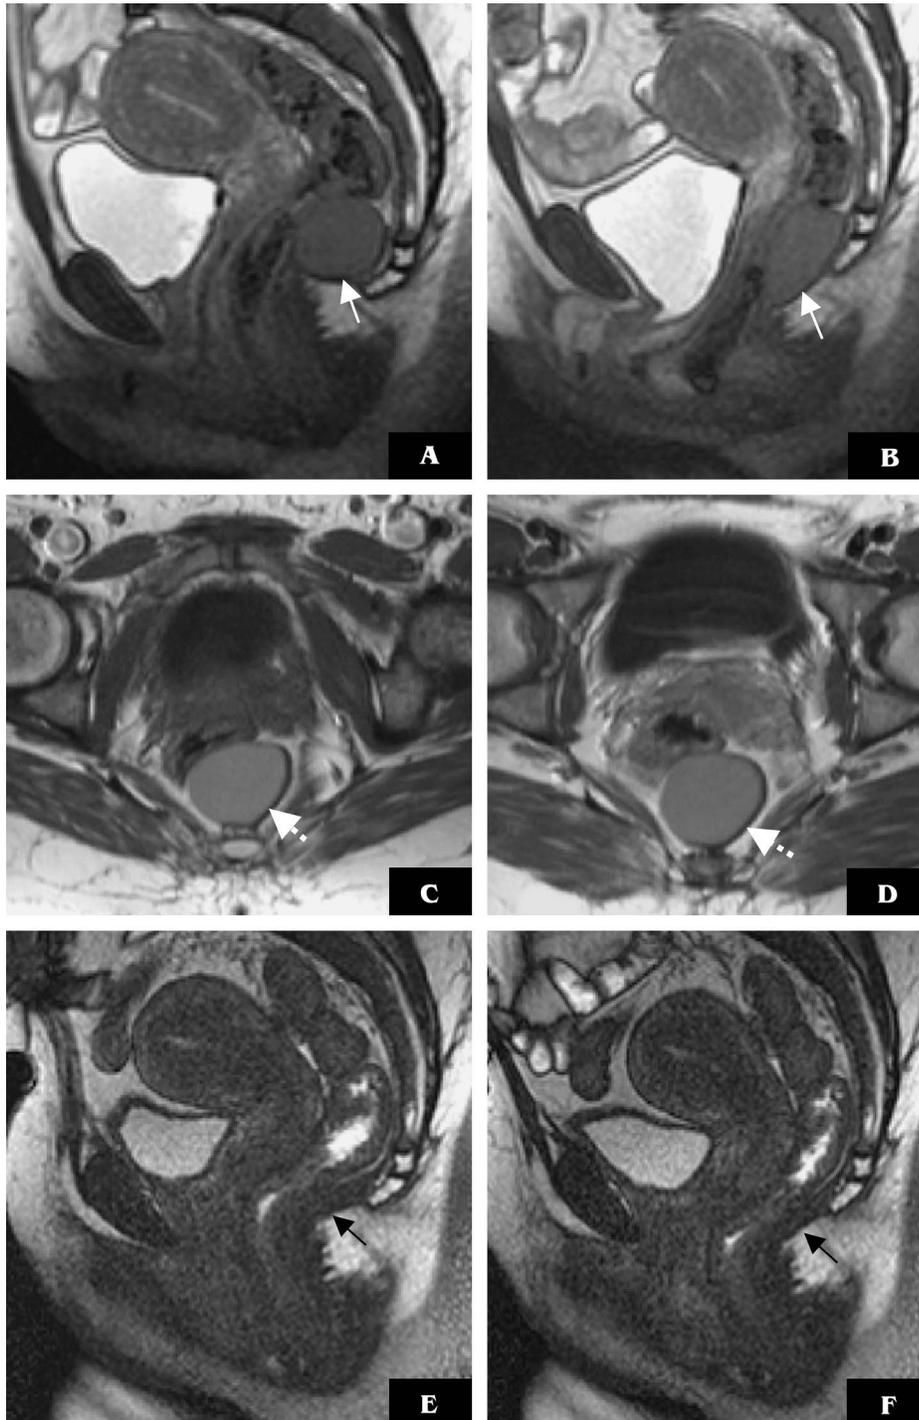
Images from a 40-year-old female with stress urinary incontinence and a posterior compartment mass. An atypical rectocele likely containing debris or tissue was diagnosed on clinical examination. A, B, Sagittal balanced fast field echo MR images (5/1.6 [repetition time (ms)/echo time (ms)]) at rest (A) and at strain (B) show an ovoid mass of intermediate signal intensity that moves with the levator plate (arrows). C, D, Axial pre- and post-contrast T1-weighted TSE MR images (550/14 [repetition time (ms)/echo time (ms)]) show no enhancement or wall nodularity to suggest a neoplasm (dashed arrows). Benign cystic mass lesion was the leading diagnosis. E, F, Sagittal Balanced fast field echo MR images (5/1.6 [repetition time (ms)/echo time (ms)]) at rest (E) and at strain (F) show an intact levator plate (arrows) following excision of the mass, identified as a simple epidural cyst at surgery.
